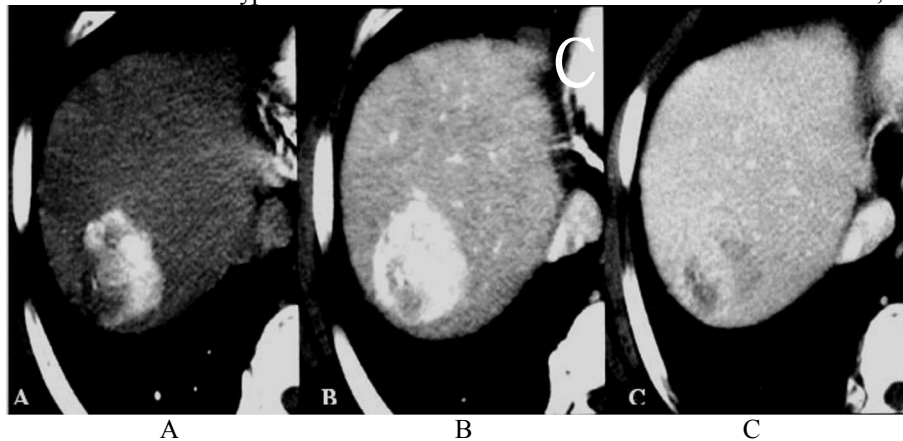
Axial CT images of the liver show hepatocellular carcinoma which is 35 mm in diameter. (A) Early arterial phase. (B) Late arterial phase. (C) Portal venous phase. Images of the early and late arterial phase and the washout of contrast medium on the image of the portal venous phase, the tumor goes to show marked contrast improvement⁽⁴⁷⁾.
